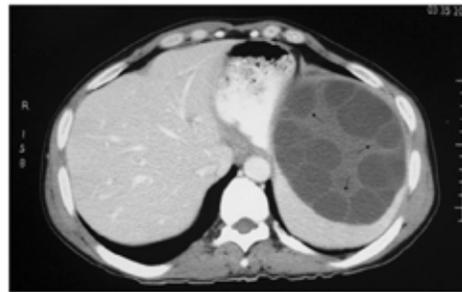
CT Scan showing Hydatid cyst
